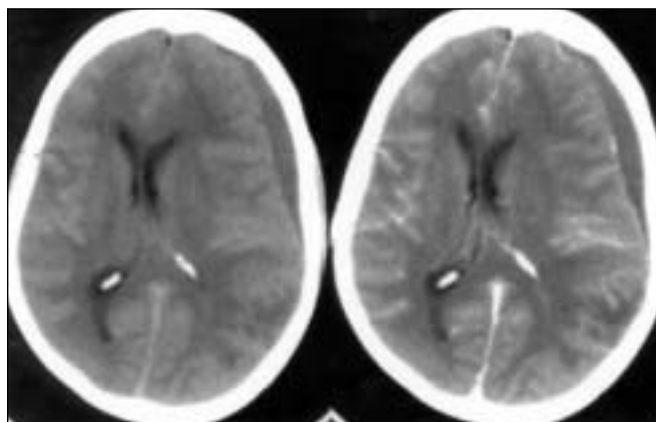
Plain and contrast CT scan of the brain done on 09/11/2003 shows a left fronto-parietal hypodense, extracerebral fluid collection with severe brain edema causing midline shift and obliteration of the basal cistern
